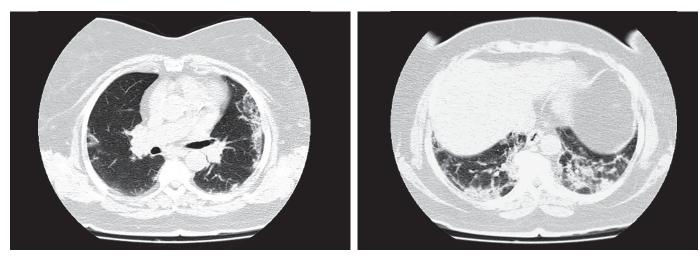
Follow-up chest-CT on day 7.
